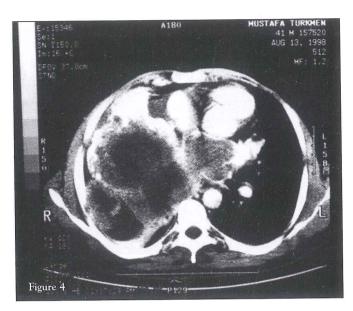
Thorax CT of the patient eleven years after the first diagnosis of GCTB
